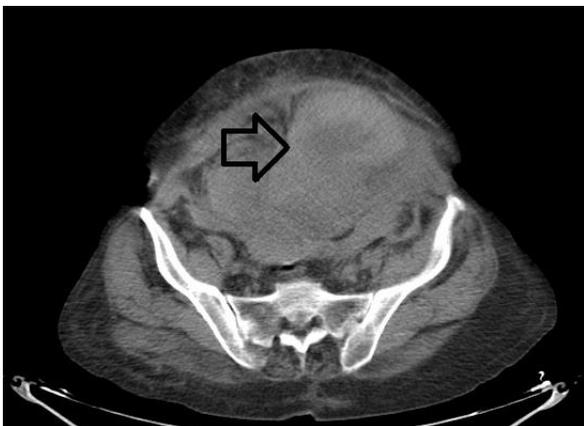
Computed tomography shows an anterior pelvic hematoma
